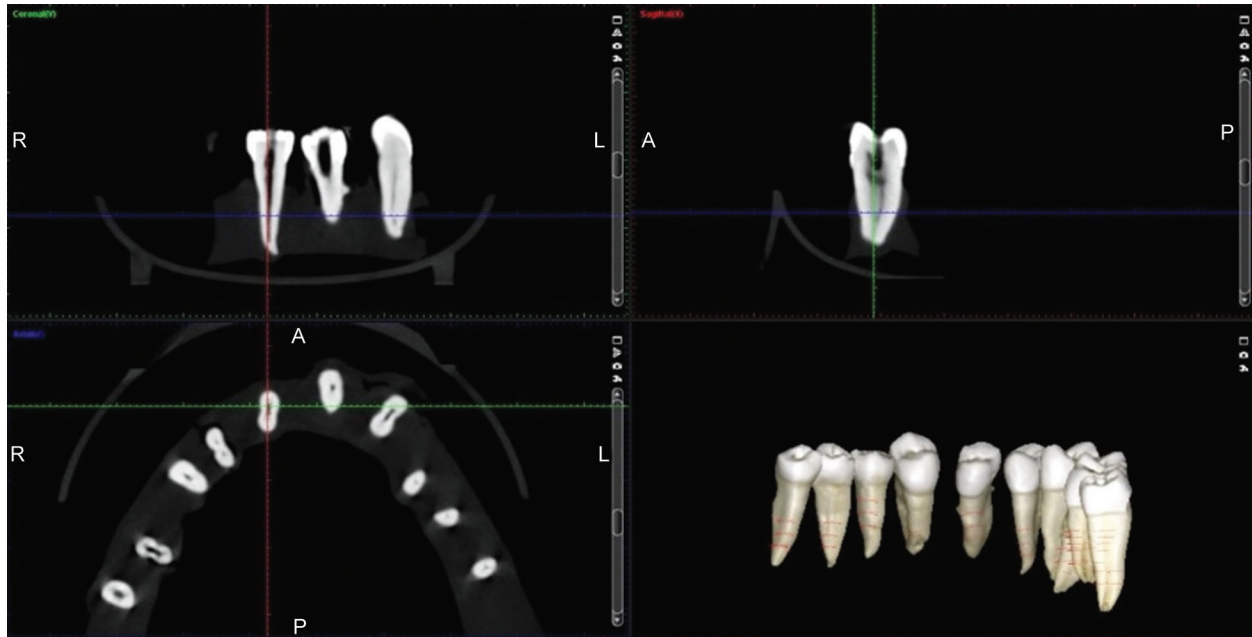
CBCT image representing the selection of oval-shaped curved root canals
